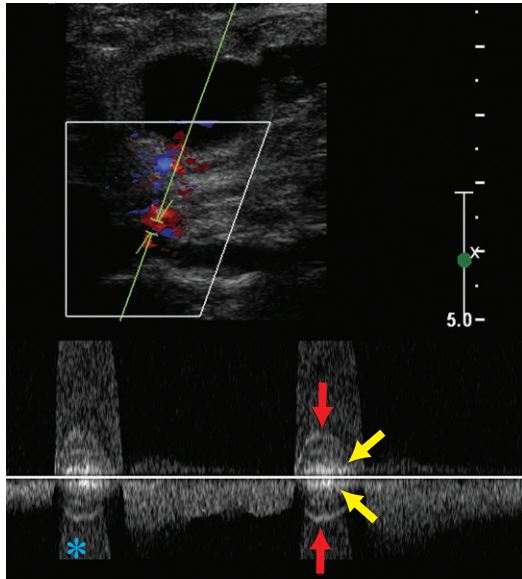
As the same patient as [Figure S32-1](#), the spectral Doppler near the common femoral artery shows the typical to and fro waveform from the neck of the pseudoaneurysms (the flow into the waveform is aliased [°]). The fro portion is below the baseline. Inside the systolic portion of the waveform is a bright area above and below the baseline (yellow arrows). These are spectral bruits and they demonstrate both directions because vibrating tissue does not have a single direction. The curved signal above and below are harmonics of the bruit (red arrows).
